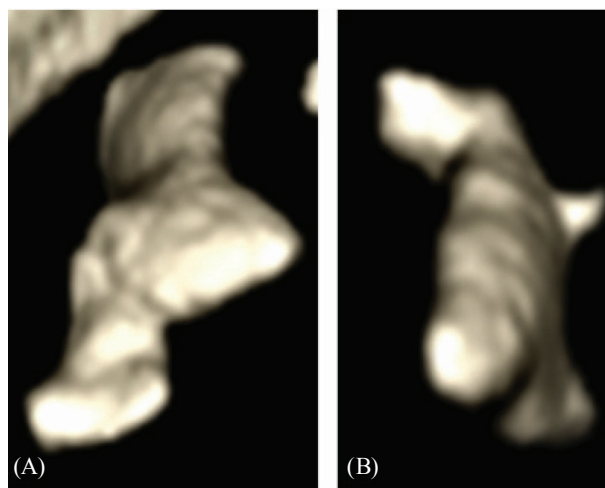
Reconstructed 3-Dimensional CT images of Right (A) and (B) Left staghorn.
